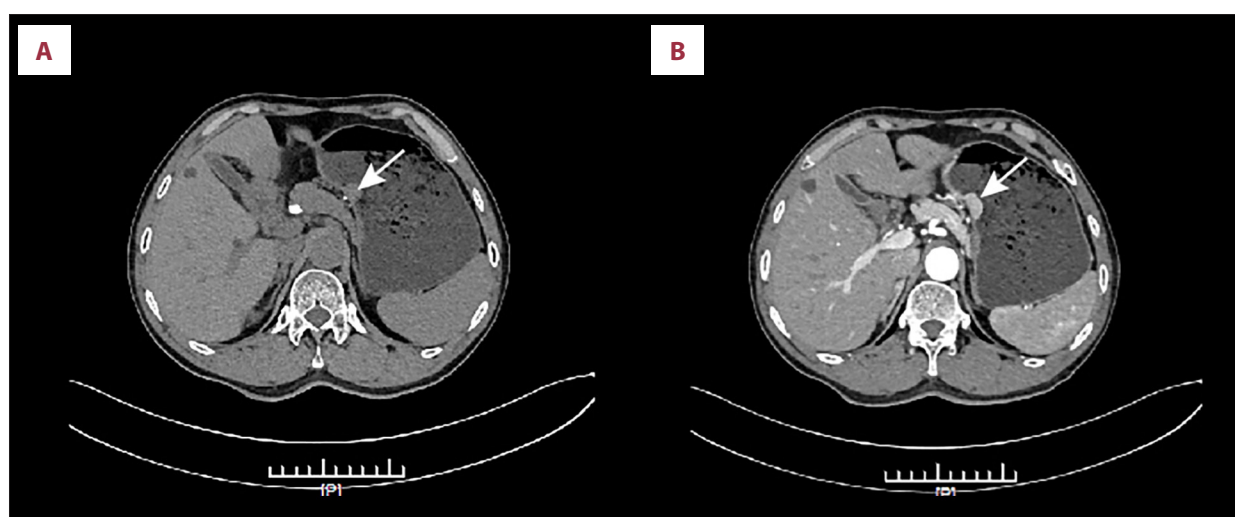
(A) Contrast-enhanced computed tomography reveals a well-circumscribed, exophytic, submucosal tumor in the lesser curvature of upper stomach at the venous phase. (B) The tumor is shown enhanced at the arterial phase.
